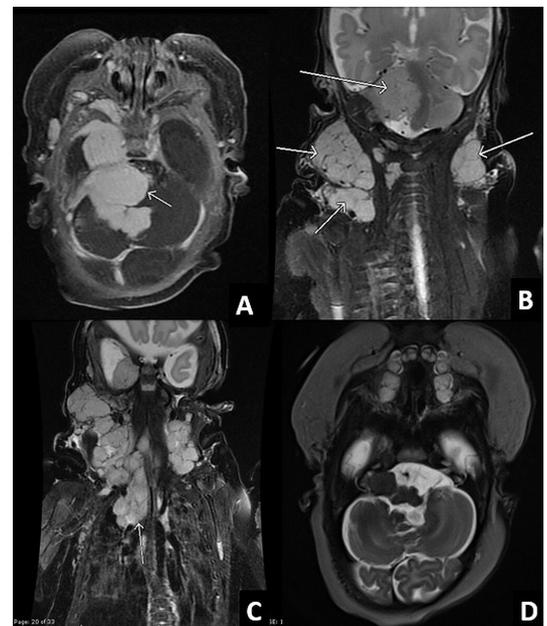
Cerebral, neck and thoracic MRI (A) Axial T1 postcontrast MRI of the posterior fossa demonstrating the avidly enhancing haemangioma centred on the right cerebellopontine angle, compressing the brainstem (arrow) and extending into the right middle cranial fossa. (B) Coronal T2 fat-saturated MRI of the head and neck demonstrating the right posterior fossa haemangioma causing brainstem compression and bilateral neck haemangiomas. (C) Coronal T2 fat-saturated MRI of the head and neck demonstrating the extent of the bilateral neck haemangiomas extending inferiorly into the mediastinum (arrow). (D) Follow-up MRI performed at 4 months of age. Axial T2 sequence demonstrating a significant reduction in size of the posterior fossa haemangioma with treatment.
